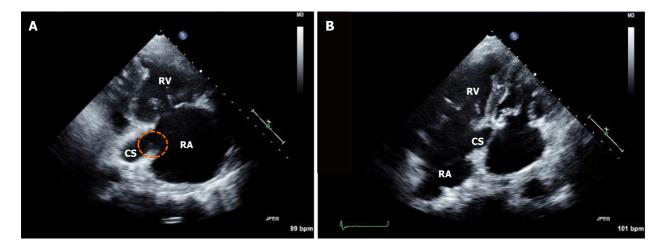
Follow-up echocardiographic imaging. A: Right ventricular inflow; B: Modified apical four-chamber views showing a remnant vegetation at the coronary sinus ostium (dotted circle). RA: Right atrium; RV: Right ventricle; CS: Coronary sinus.
